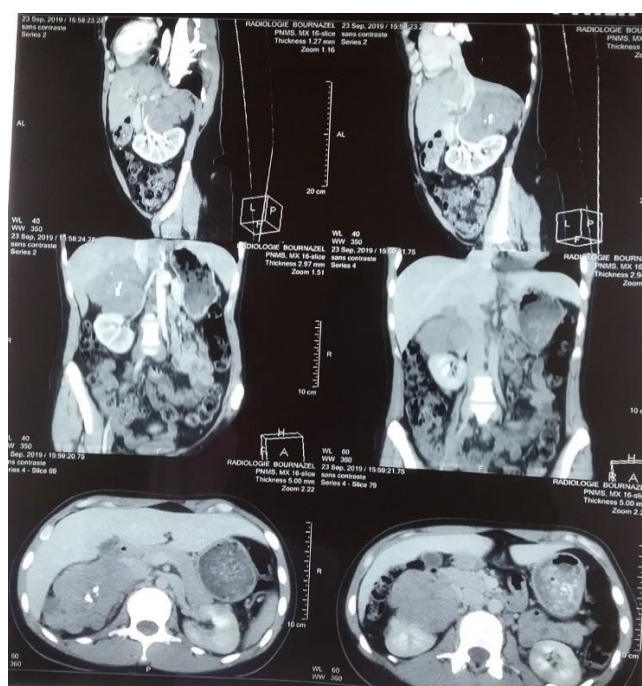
CT Showing Right Adrenal Mass
